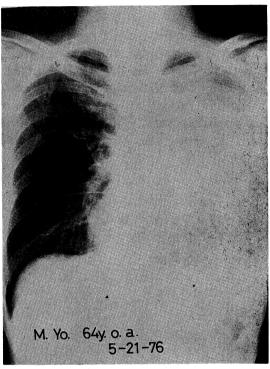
Case 1 in Table 4. Posteroanterior roentgenogram reveals a pattern of collapse of the left lung.
